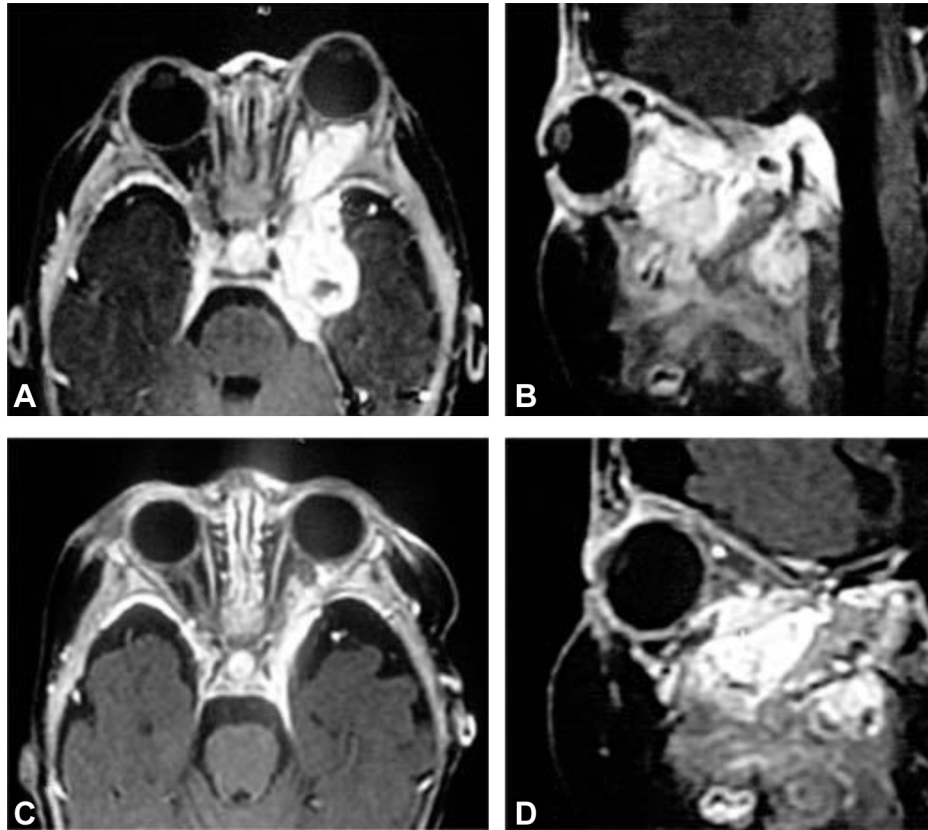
Magnetic resonance imaging (MRI) of an 11-month-old female patient. (A) Axial and (B) sagittal fat-suppressed T1-weighted spin-echo (SE) with gadolinium injection. The imaging shows the lesion has invaded into the whole left orbital cavity, pterygopalatine fossa, middle cranial fossa, and intracalvarium. MRI of the same patient 2 weeks after intralesional injection with corticosteroid: (C) axial and (D) sagittal fat-suppressed T1-weighted SE with gadolinium injection show the lesion has disappeared almost completely.
